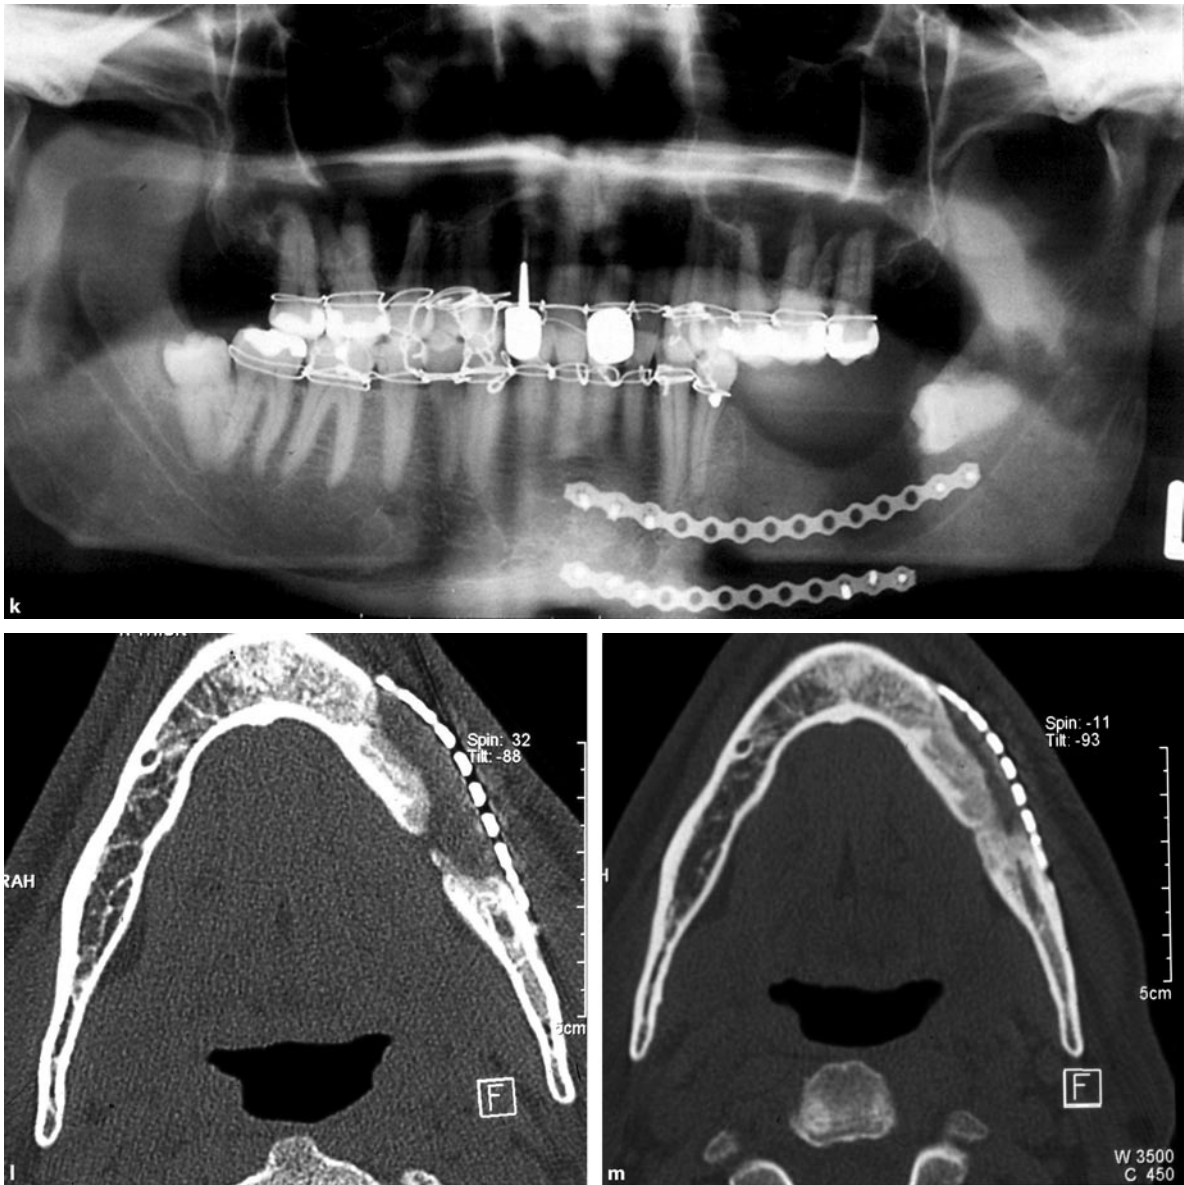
m (continued) The tooth and the remaining attached bone formed a sequester surrounded by granulation tissue, with no remaining contact to the mandibular bone. Postoperative orthopantomography after surgical debridement and decortication in the left mandible with removal of the second premolar as well as the first and second molar teeth (k). The left third molar was not involved in the infected area and hence was left remaining for stability reasons. The left mandible is stabilized by
